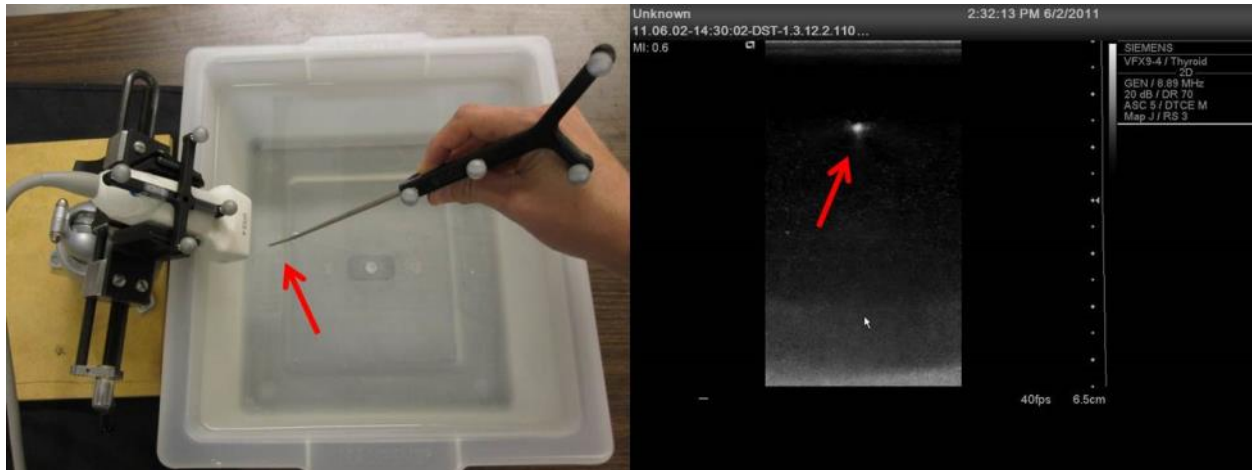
Spatial calibration setup. A tracked probe is inserted into the ultrasound beam (left) until the tip produces a bright dot in the image (right). This is done repeatedly to establish the transformation between image space and sensor space.
